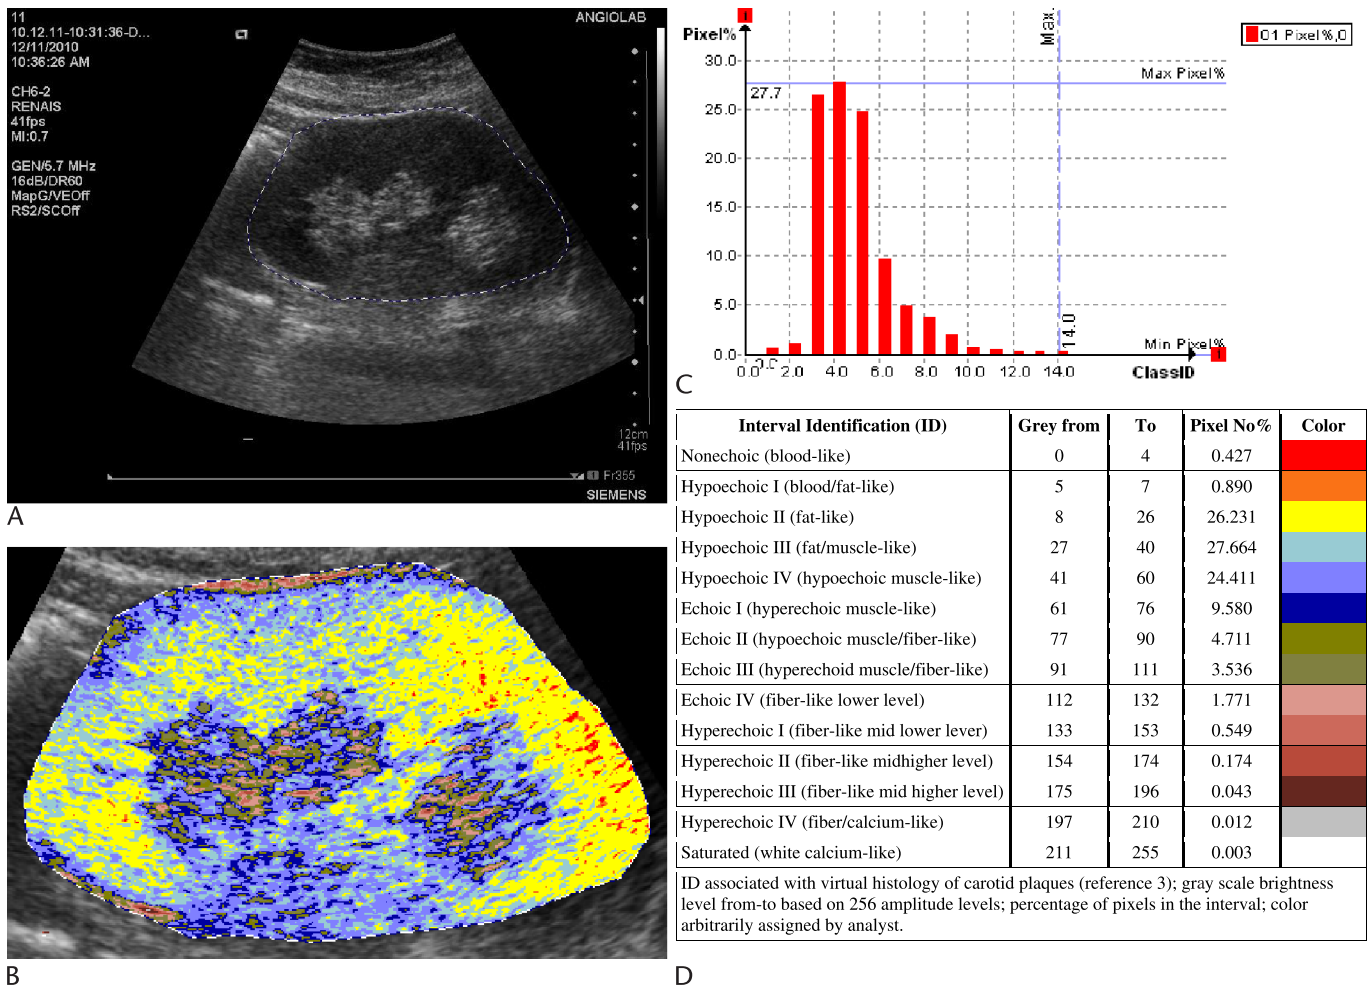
Example of virtual USTC applied to a normal young kidney. A, B-mode image from a common ultrasound instrument. B, Colorized image representing various pixel brightness levels. C, Histogram showing pixel brightness distribution. D, Table defining 14 levels of grayscale pixel brightness transformed into artificial colors.
